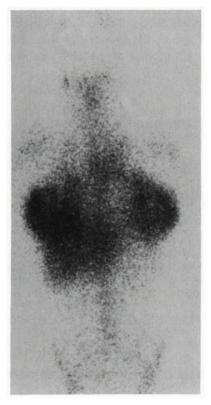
Gallium scintigraphy with bilateral postpartum breast activity.
